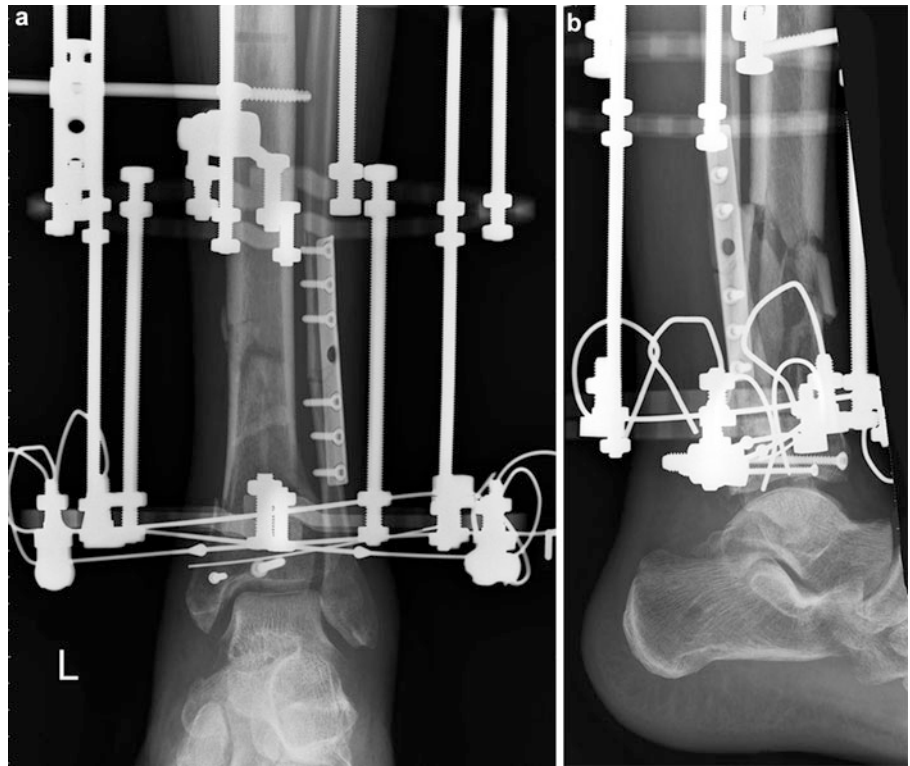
(a, b) Eight-month AP and lateral X-rays of reconstructed pilon fracture with shaft extension. Clinical exam revealed 3° of ankle dorsiflexion, 30° plantar flexion, and >5° inversion eversion. Returned to work
